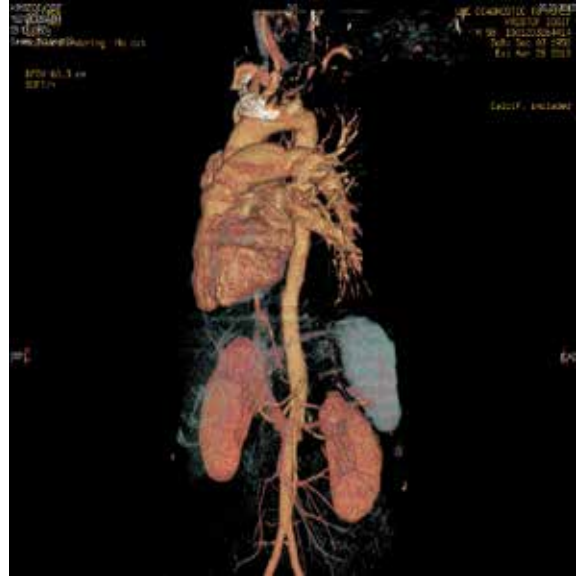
CT angiography. Right pulmonary artery atresia
